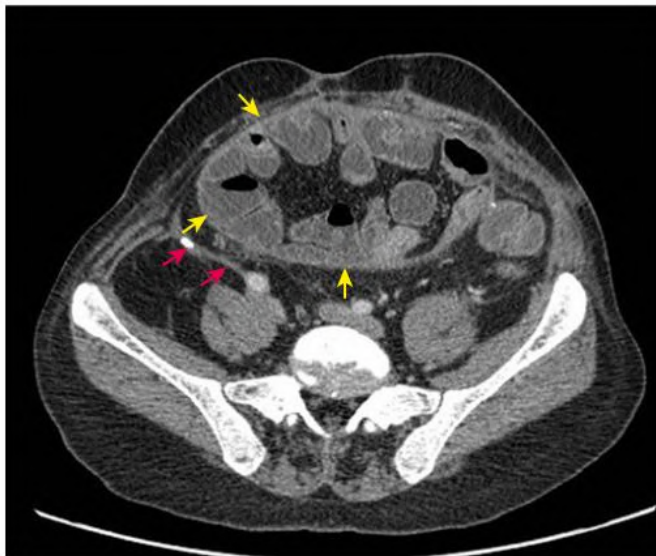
Encapsulating Peritoneal Sclerosis. Abdominal computed tomography scan from a patient with encapsulating peritoneal sclerosis. Red arrows indicate thickened parietal peritoneum with calcification; yellow arrows indicate thickened visceral peritoneum forming a cocoon containing loops of bowel.
